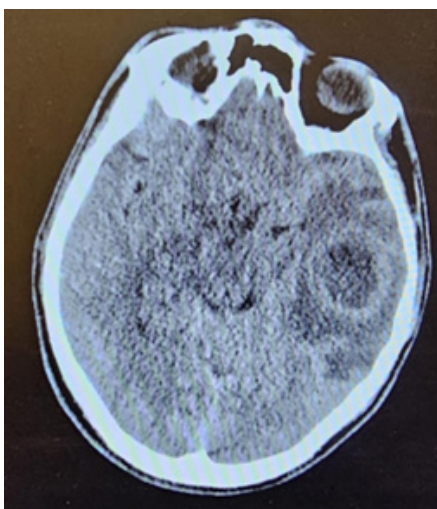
Axial non-contrast brain computed tomography demonstrating a hypodense lesion in the left temporal lobe consistent with a brain abscess. Prominent surrounding vasogenic edema is seen in the adjacent parenchyma. The lesion is located adjacent to the temporal bone, supporting an otogenic origin in the setting of chronic otitis media and mastoiditis.
